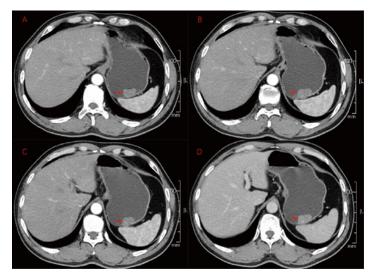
Enhanced CT scan of upper abdomen: (A,B) Arterial phase shows the tumor is in the posterior wall of the fundus, as indicated by arrows; (C) Arterial phase showing a small portion of the tumor is extraluminal, abutting the spleen, indicated by arrows; (D) The venous phase shows the fundus tumor, indicated by the arrow.
